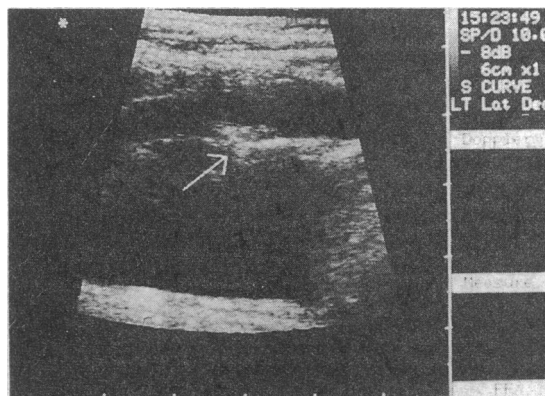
B mode ultrasound image from a duplex scan showing an echodense atheromatous plaque in the carotid artery (above the arrow) causing about 50% stenosis
